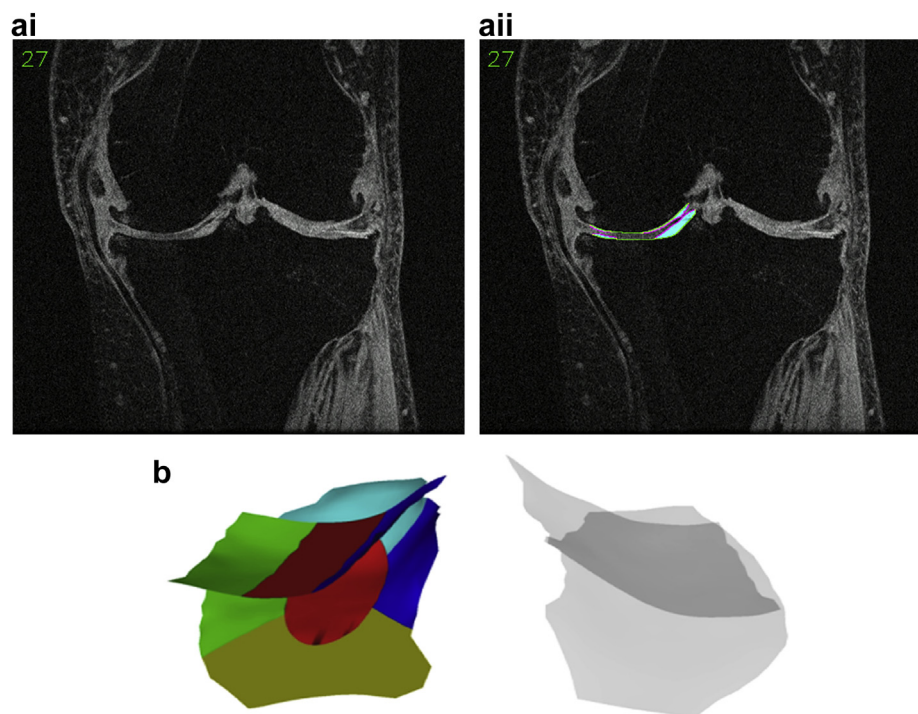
(a) Sagittal magnetic resonance images (MRI) acquired using SPGR sequence. Both images depict the same slice of the MFTC. The image on the right shows the segmentation of the cartilage (magenta = segmentation of the cartilage surface; green = segmentation of the total area of subchondral bone = tAB) and the filling between the two surfaces in turquoise. The image of the MFTC shows an area of denuded subchondral bone (dAB) in the weight-bearing aspect of the medial femoral condyle (cMF) and medial tibia (MT). (b) Visual display of the medial femorotibial subregions. Posterior view of the femorotibial compartment of the knee (middle), inferior view of the weight-bearing femur (top), and superior view of the tibia (bottom). Color codes for both the femoral and tibial plates: red = central subregion, green = external subregion, blue = internal subregion, yellow = posterior subregion, turquoise = anterior subregion.
